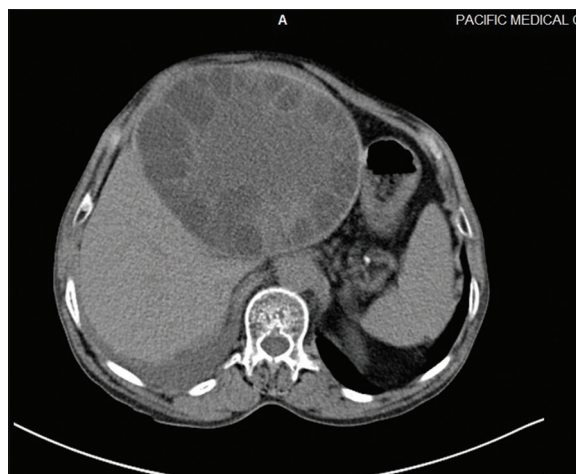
Computed tomography abdomen axial view showing hydatid cyst
